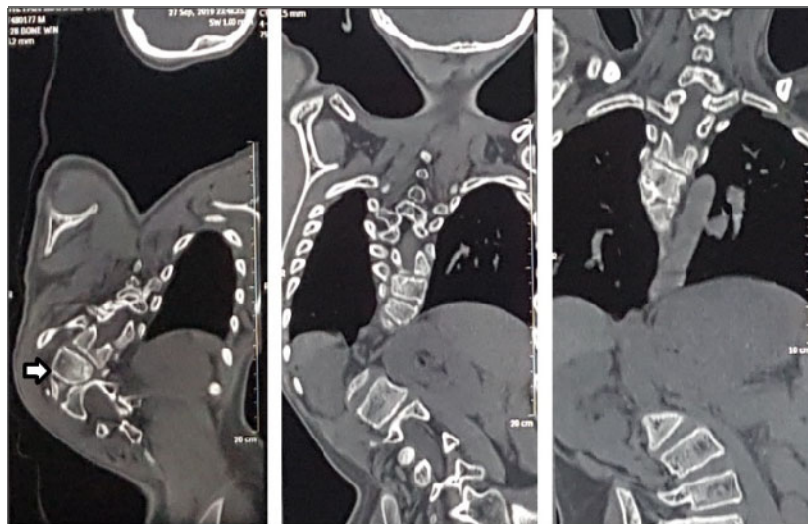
Preoperative serial CT scans (coronal view) of spine showing kyphoscoliotic deformity with right sided convexity in coronal plain (arrow pointing towards D12 hemivertebra).
